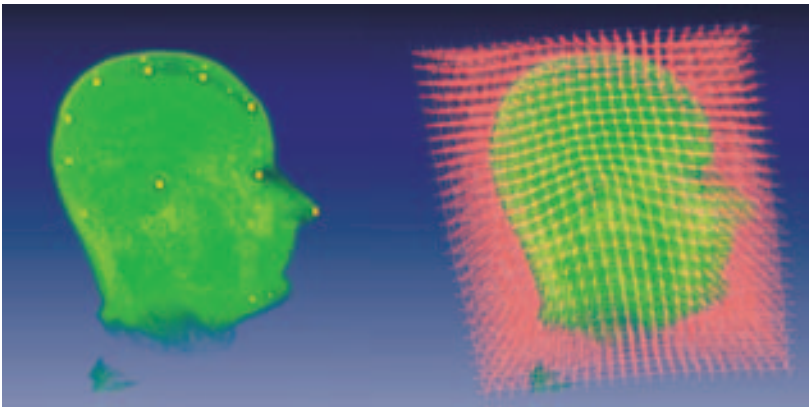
a) Positionierung des herkömmlich rekonstruierten Kopfes in einem CT Scanner b) Genaue Ausrichtung des Kopfes im Iso-zentrum des Philips Spiral CT Scanners.
